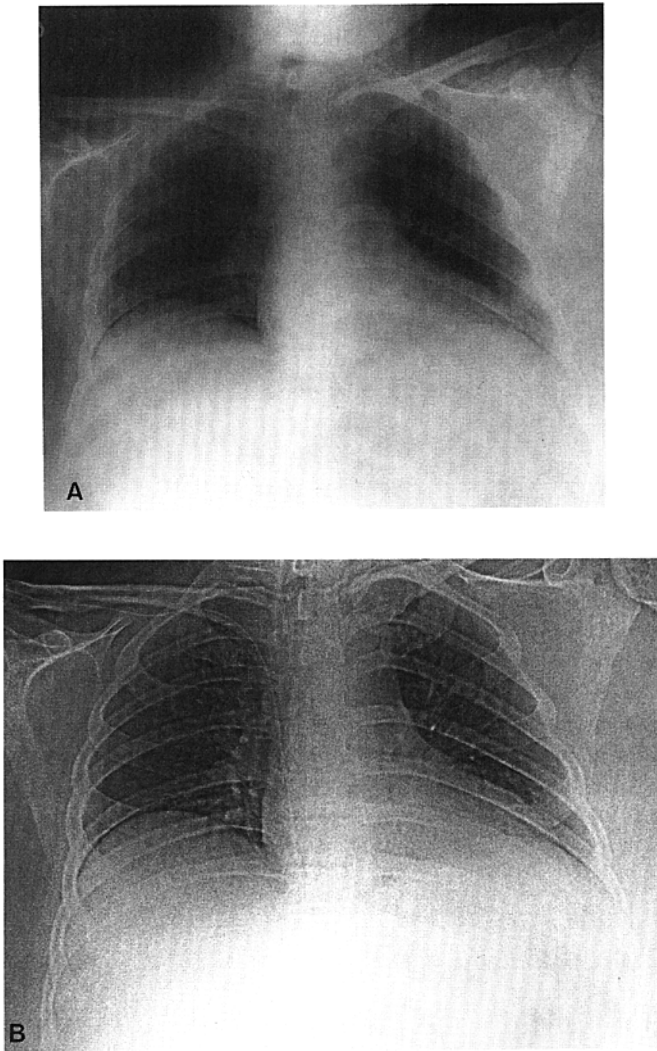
(A) Digitized chest radiograph without image manipulation in an obese patient does not allow for image of the lung parenchyma and mediastinum on the same image. (B) Edge enhancement of the image improves the density balance but distorts the lung parenchyma.
